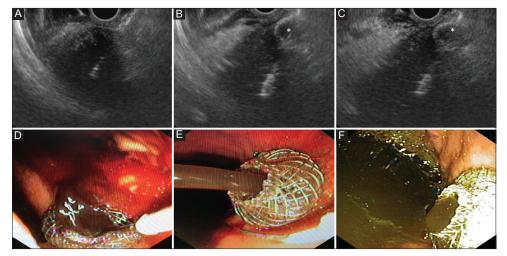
(A) Endosonographic view of the catheter of the lumen-apposing metal stent (LAMS) advancing in a peripancreatic fluid collection; (B and C, white asterisk) deployment of the distal flange of the LAMS; (D) endoscopic view of the deployment of the distal flange of the LAMS; (E and F) gradual emptying of the collection within the gastric lumen
